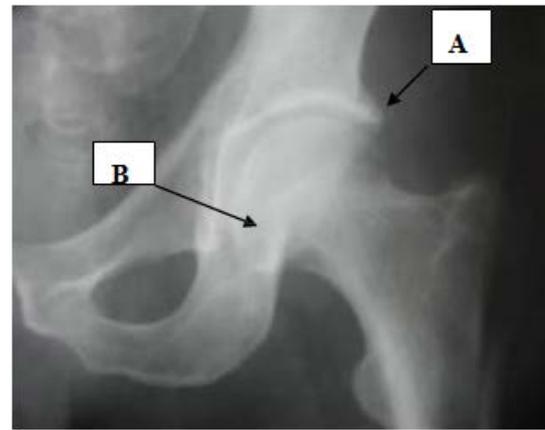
X-ray film of coxarthrosis stage II. A: Marginal osteophytes; B: Deformity of the femoral head
